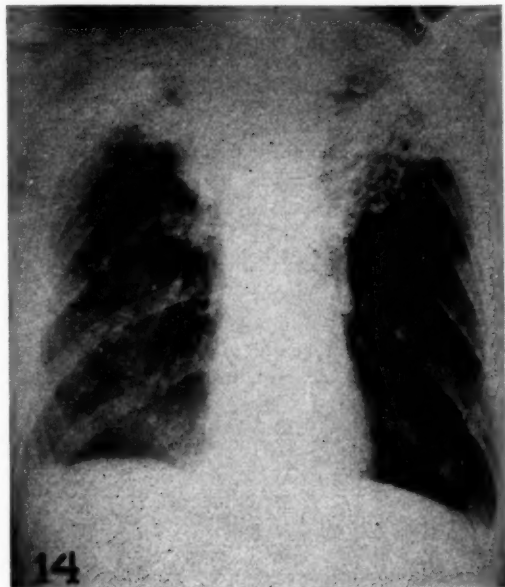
Case 7. Roentgenogram showing fibroid upper, emphysematous bases.
